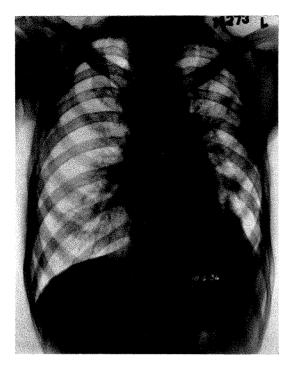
Roentgenogram of chest of Case xvi, after nine months of radiation therapy. Note increased density of lung fields, especially on left.
